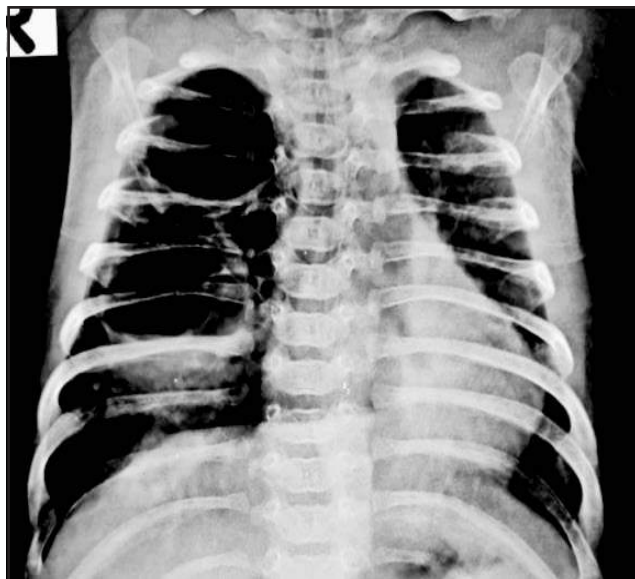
X-ray report at the age of 2 months
